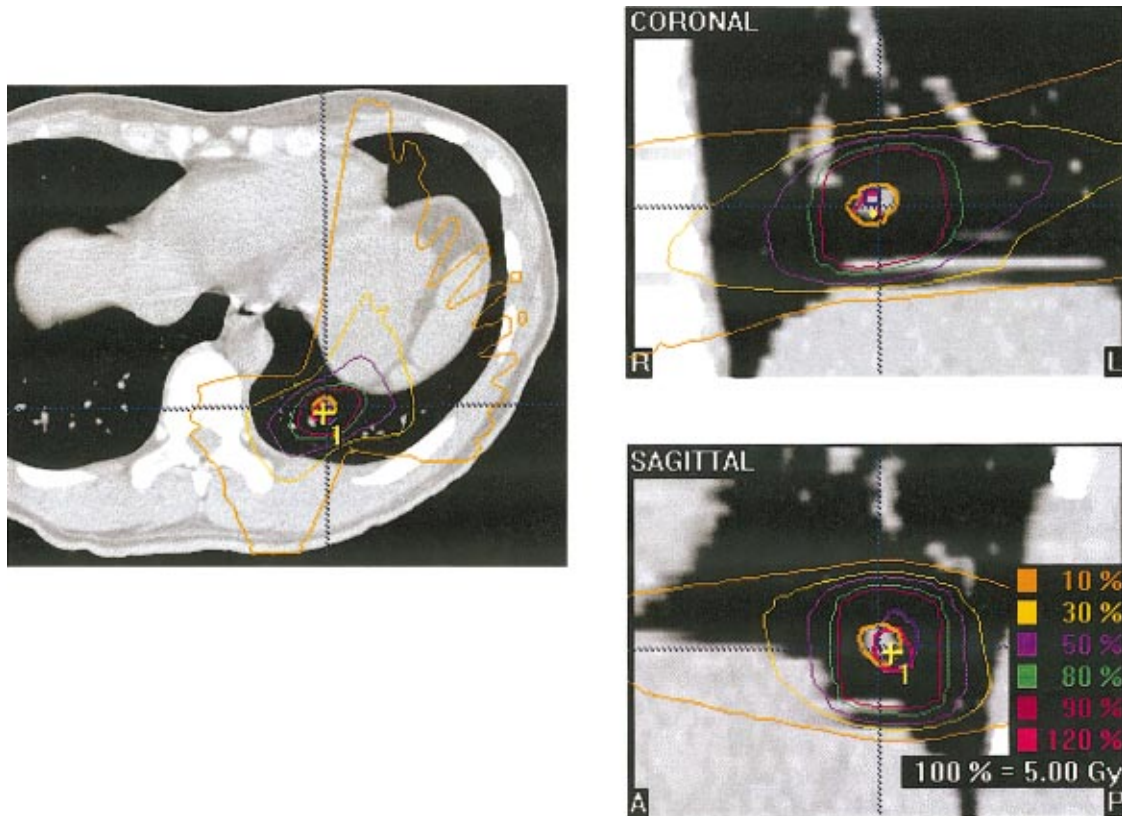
Isodose contours overlaid onto a CT image of lung of cancer patient. 100% dose=5 Gy. The yellow arrow and central pink contour were manually defined to mark the location of one  $\sim 1$  cm diameter tumor. The central purple and orange contours mark the location of the tumor in subsequent CT image acquisitions. The surrounding contours (red, green, purple, yellow, and orange) are the isodose contours as described in the legend.
